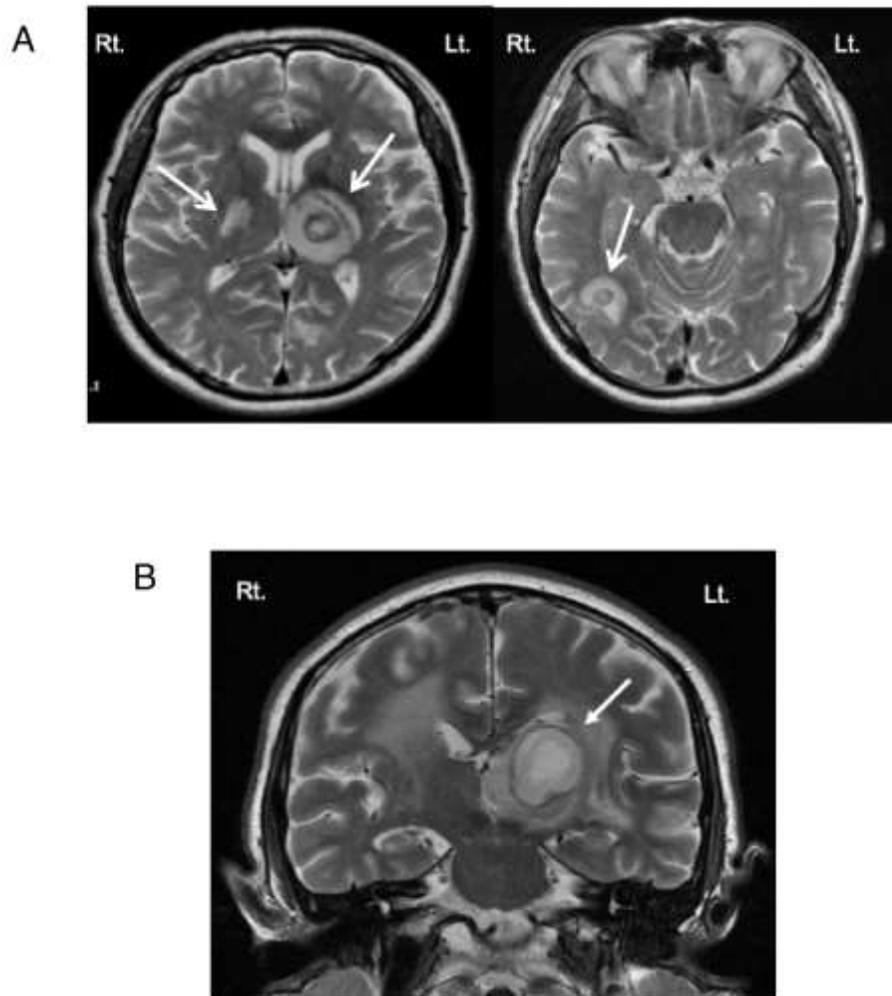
Brain MRI of the patient on admission.
